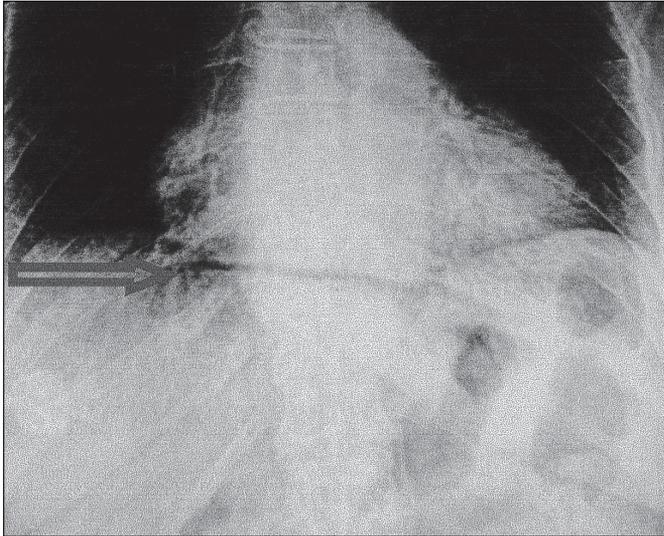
Free intraperitoneal air was clearly demonstrated by plain films of the abdomen.
